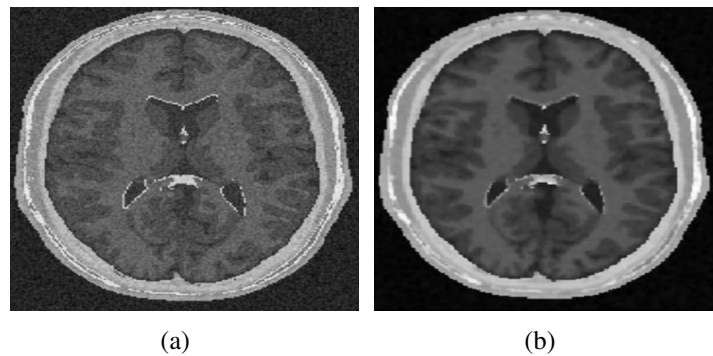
Orthogonal views of three MRI sessions obtained in a short period of time. (a) Original MRI slice. (b) Image after noise filtering. Gavidia et al. [50]
